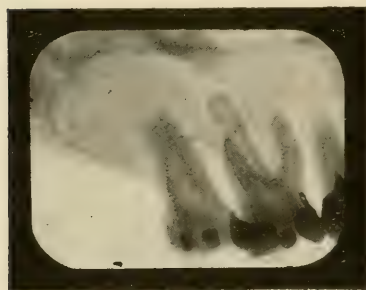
Angle of X-rays, arrow A, Fig. 440.
